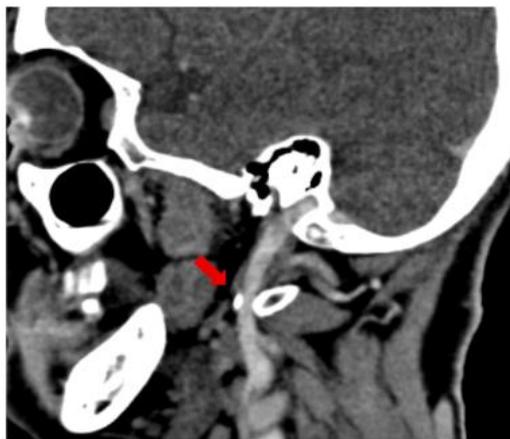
Sagittal CT image showing the stylojugular vein compression (red arrow)
